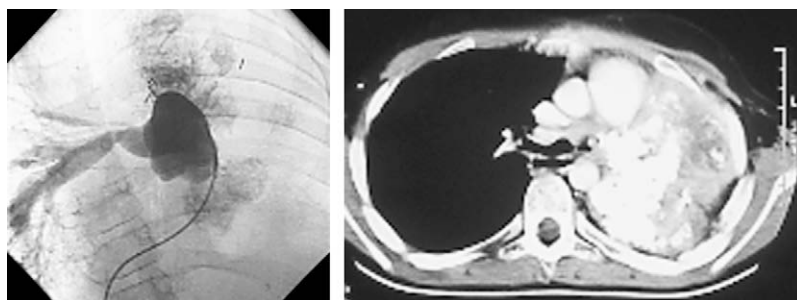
Angiography and chest computed tomography of patient 10 with an invasion of the left pulmonary artery, a tumoral stenosis of the right pulmonary artery, and an involvement of the oesophagus who had undergone operation 3 times before with uncompleted resection for an invasive mediastinal form.
